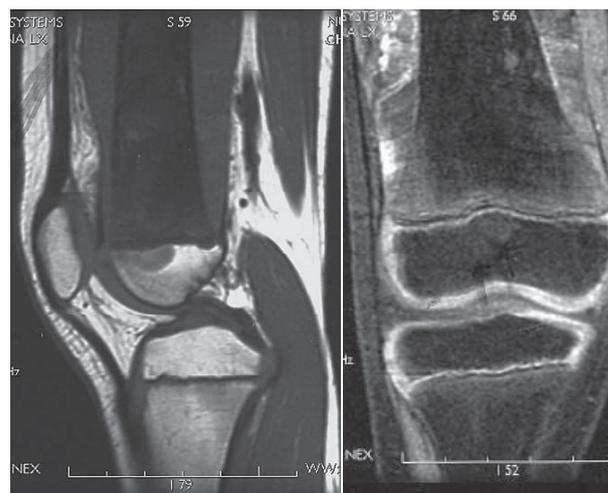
MRI of the distal femur showing trans-physeal extension of the tumour (Patient 5).
